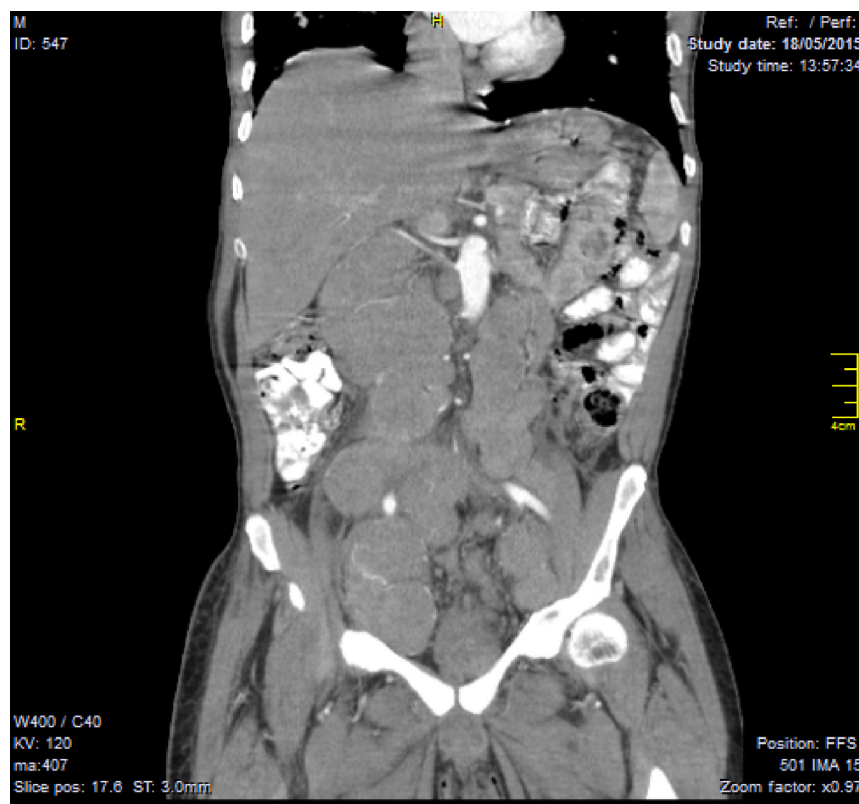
Abdominal CT showing multiple para-aortic and para-iliac isodense lesions splaying the iliac vessels.
